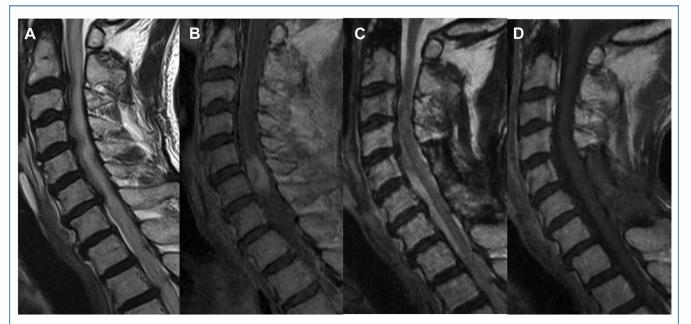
Cervical magnetic resonance imaging sagittal view, preoperatively (A and B) and 25 months postoperatively (C and D). (A) T2-weighted imaging shows extensive intramedullary signal changes and cord swelling. (B) T1-weighted imaging–gadolinium enhancement reveals diffuse
